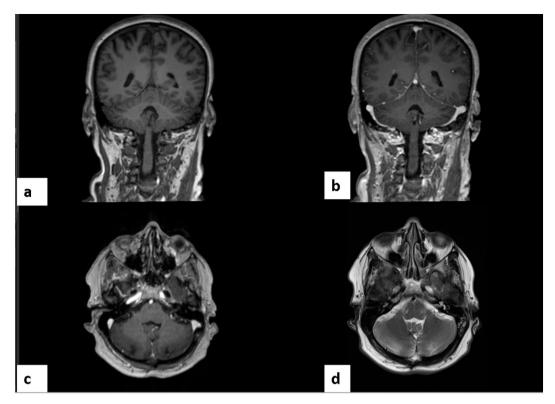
MRI follow-up three years after resection. There are no evidences for tumour relapse.
